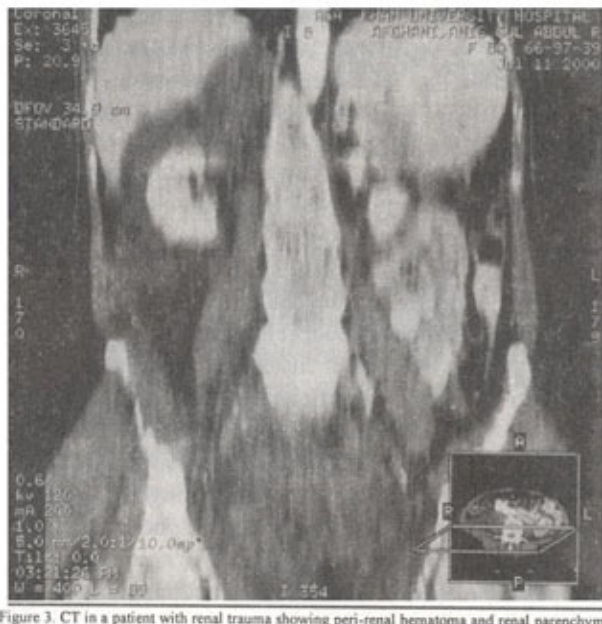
CT in a patient with renal trauma showing peri-renal hematoma and renal parenchymal lacerations, (a) before and (b) after intravenous contrast, (c and d) Sagittal, coronal reconstruction respectively, showing extent of injury extending into pedicle.
